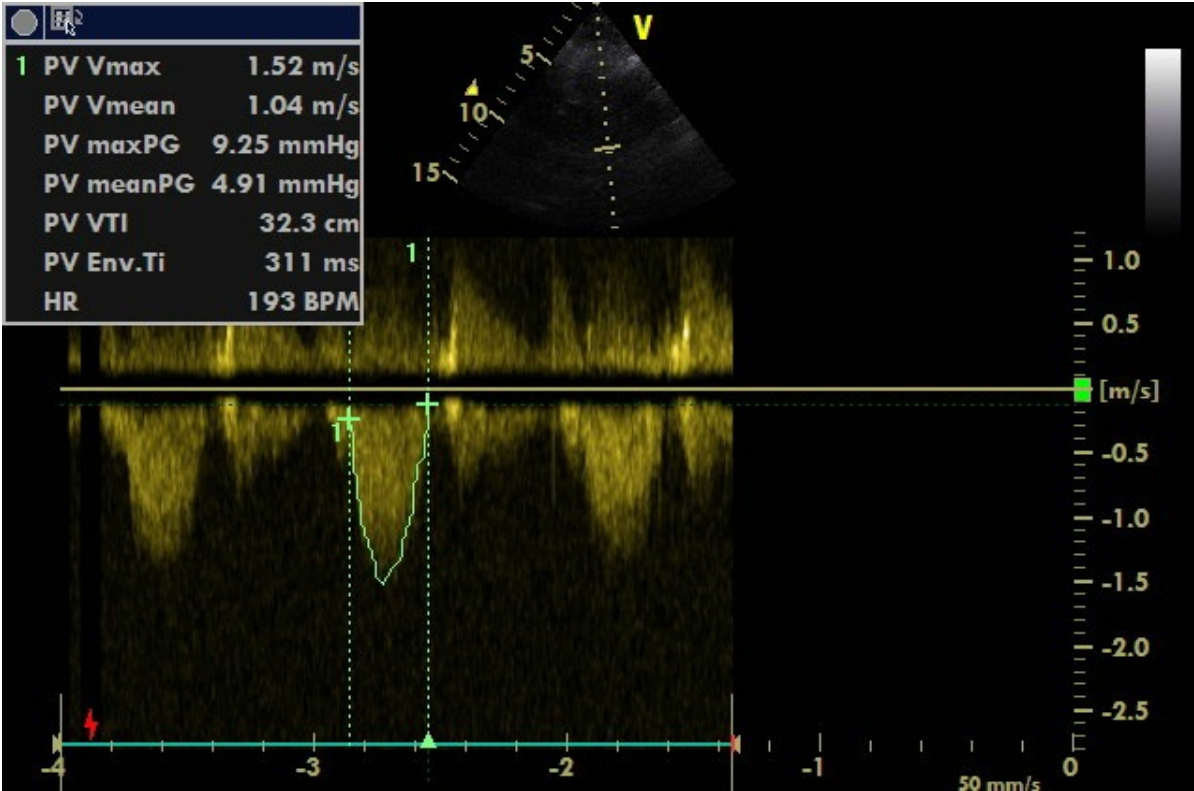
2nd year control echocardiography
